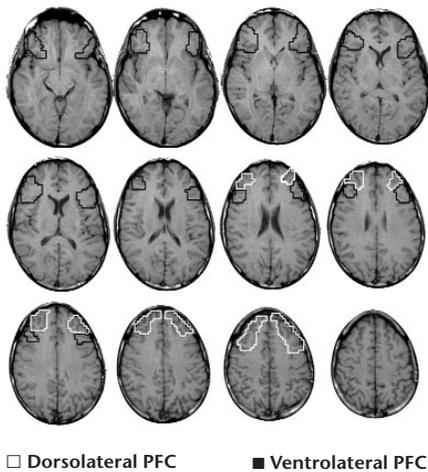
Regions of interest. Dorsolateral (white) and ventrolateral (black) regions of interest (ROIs) superimposed on T1-weighted images from one subject's brain.
